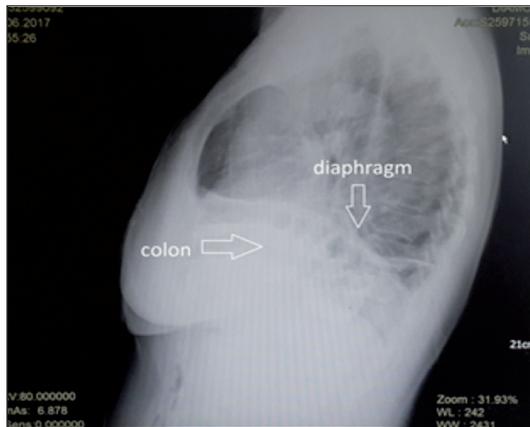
Lateral chest X-ray demonstrates an intact diaphragm with colonic loops below the diaphragm.
